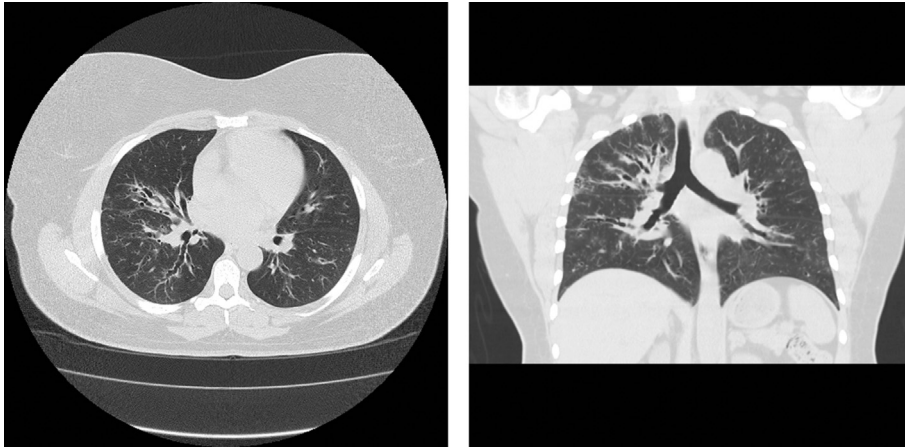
a - HRCT Axial. b - HRCT Coronal.
